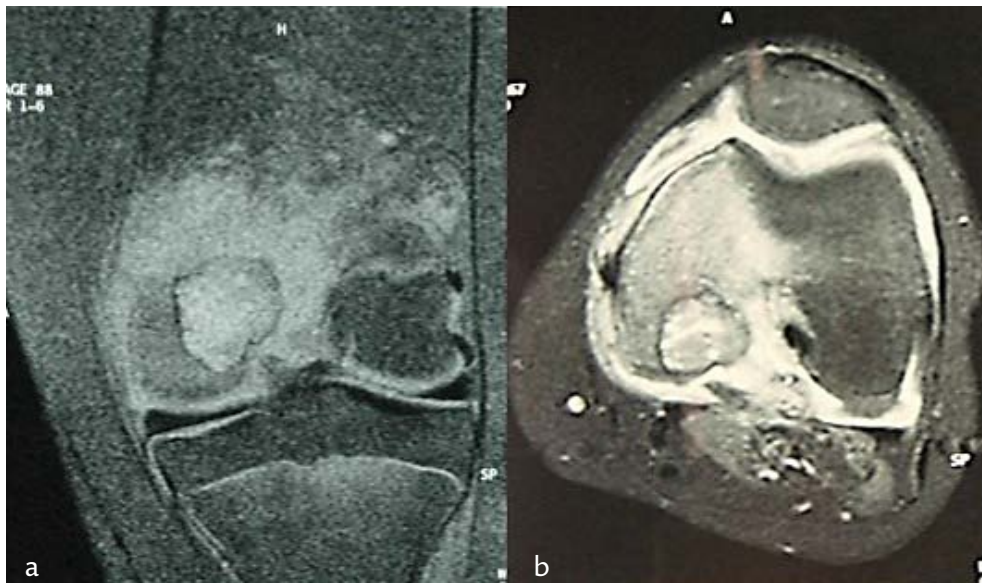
MRI of the knee showing a lesion hypointense on T1-weighted and hyperintense on T2-weighted images.
